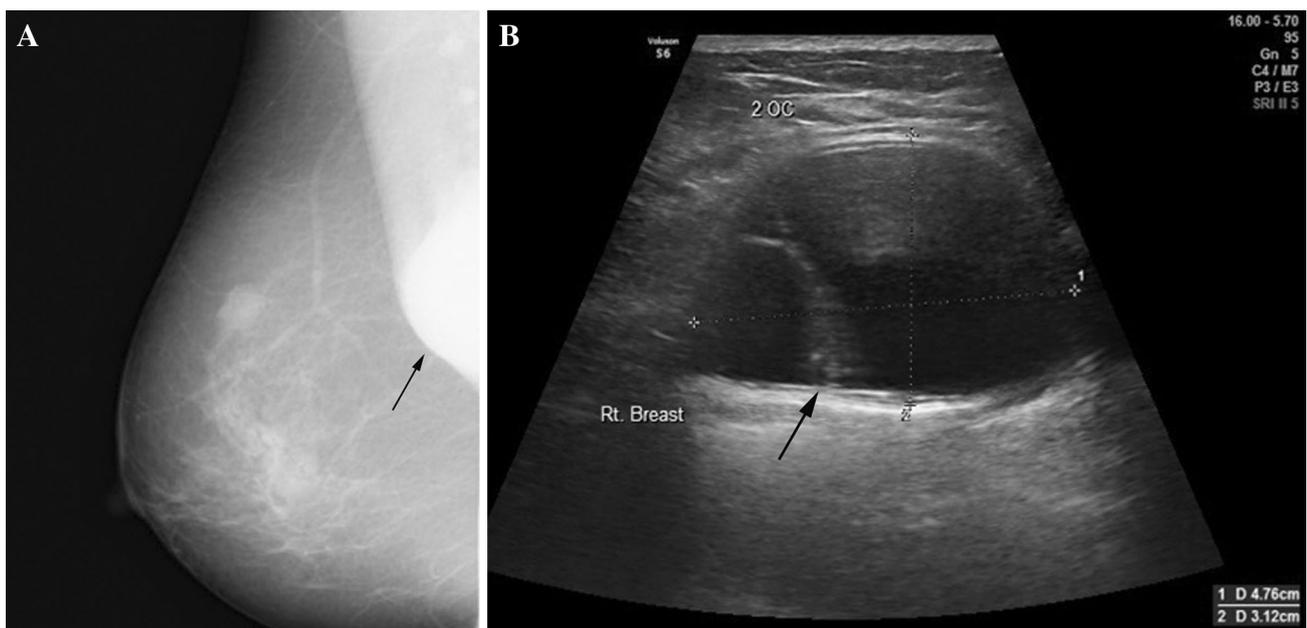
a, b (mammography panel): X-ray mammography of the right breast showing a partially marginated oval shaped radioopaque lesion in upper-inner quadrant along the chest wall with margins obscured by pectoralis muscle shadow. No obvious internal microcalcification or surrounding architectural distortion seen. There also showed a well marginated, oval shaped, radio-opaque lesion
